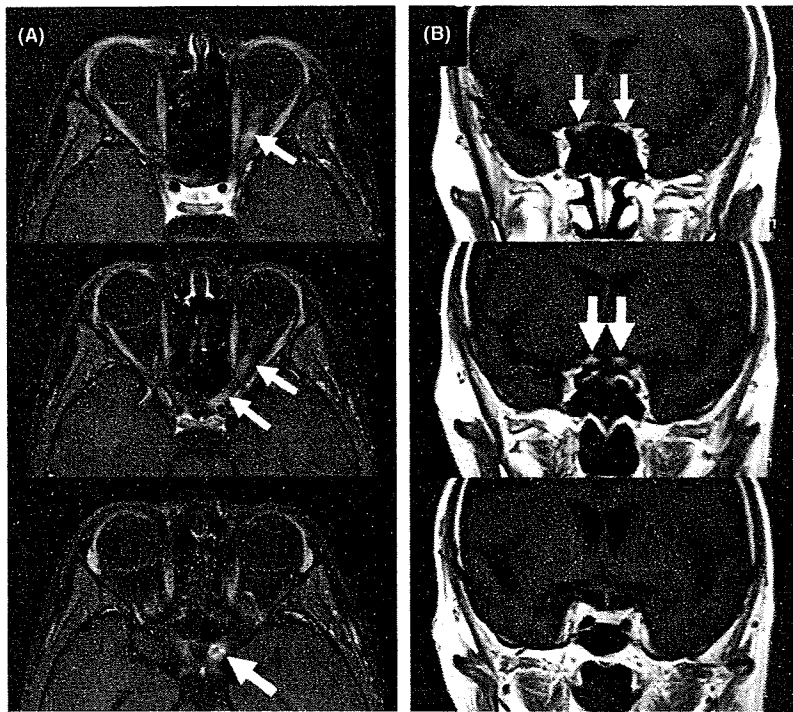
Magnetic resonance images. (A) Case 1. Axial Gd-enhanced T1-weighted images (with fat suppression) obtained at the onset of the second optic neuritis episode, showing marked enhancement of the left optic nerve (arrows), especially in the intracranial portion close to the optic chiasm (bottom). (B) Case 2. Coronal Gd-enhanced T1-weighted images obtained at the onset of optic neuritis, showing marked enhancement in the intracranial portion of the bilateral optic nerves (arrows).
